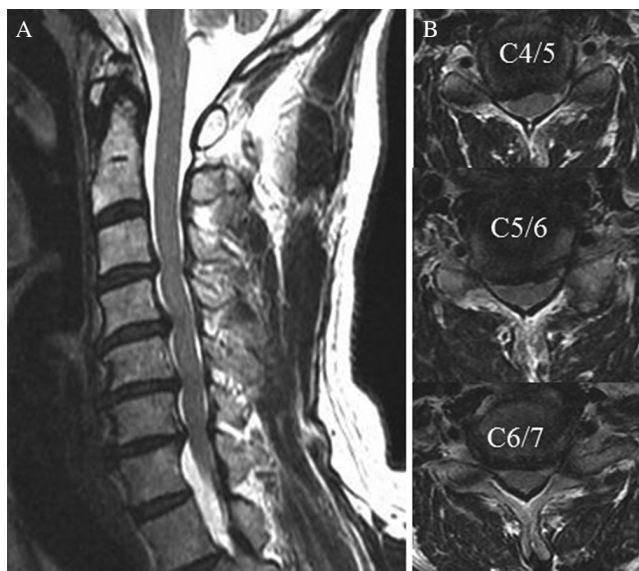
Preoperative MR images of the cervical spine show spinal canal stenosis from C3/4 to C6/7. (A) A sagittal T2-weighted image. (B) Axial T2 images at the C4/5, C5/6 and C6/7 levels.
